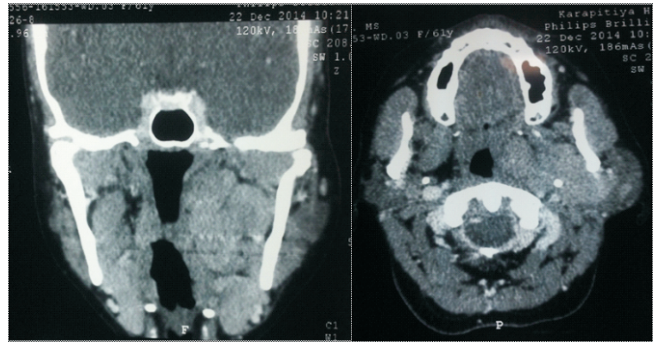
CT scan coronal and axial cut showing hyper dense deep lobe of left parotid gland
